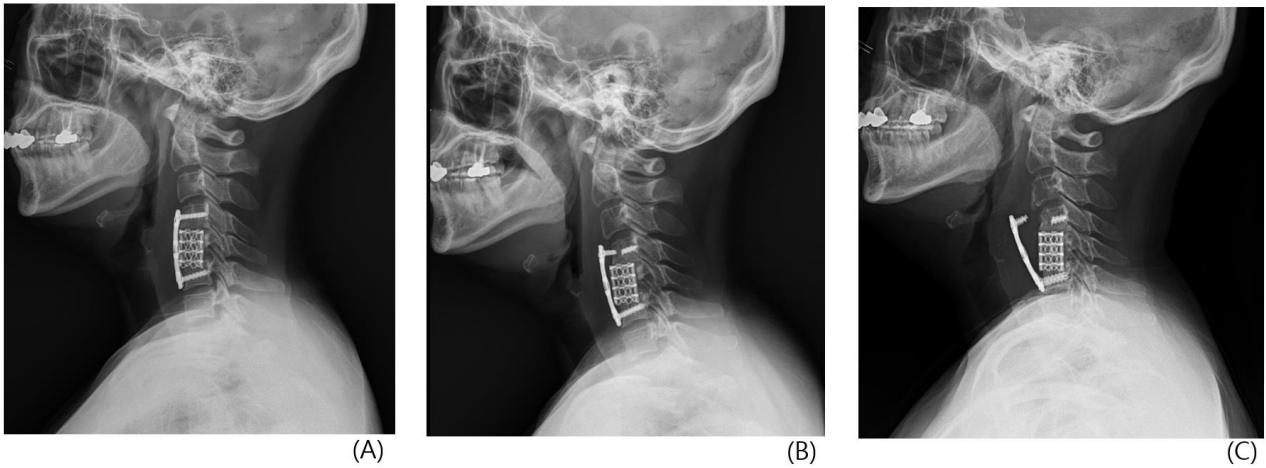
Simple X-ray of cervical spine. Sturdy placement of anterior stabilization with plate & screw in C4/5/6 (A). Fracture of upper screw was noted after 1st slip down in 2022 (B). Far displacement of plate in 2024, after 1 year from 2nd slip down (C).
